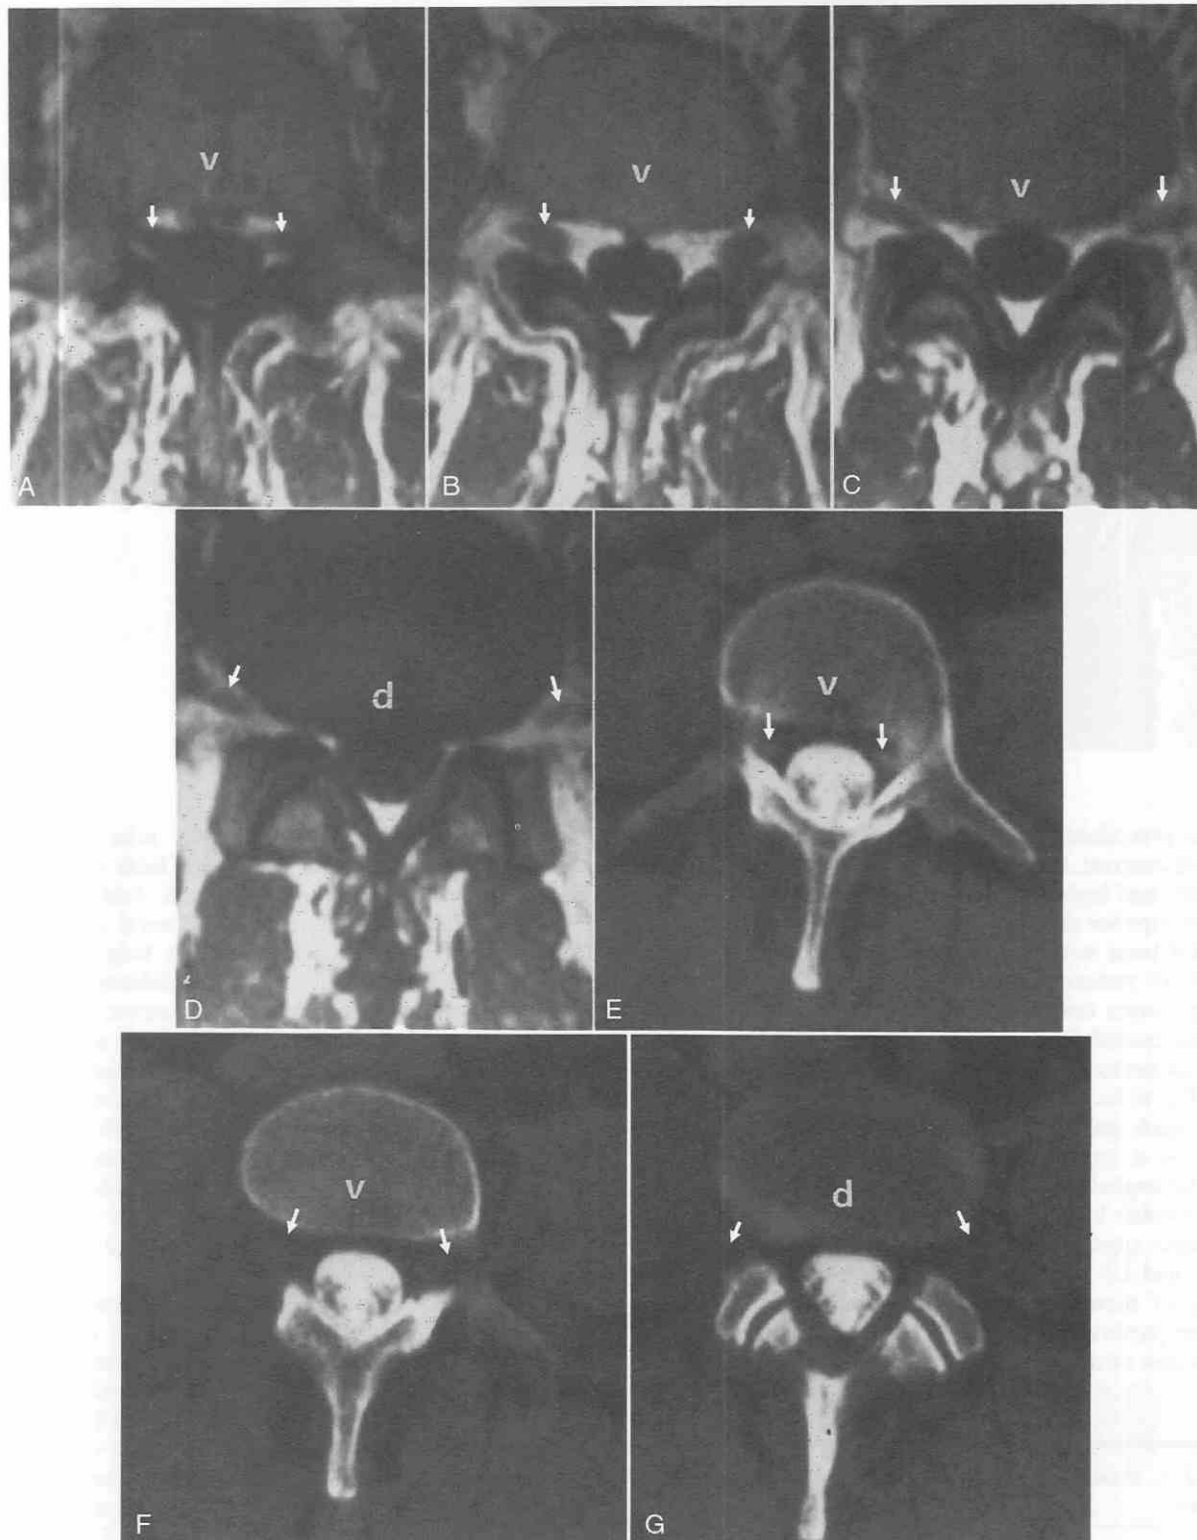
Axial T1-weighted MR image depicts the path of lumbar nerve roots through the canal. *A*, At the midbody level, the preexisting roots (*arrows*) are positioned in the lateral recesses. *B* and *C*, Just inferior to *A* at the superior aspect of the diskovertebral junction, the roots lie within the foramina. *D*, At the inferior aspect of the diskovertebral junction, the roots have already exited the foramina. *E–G*, Postmyelogram CT scan showing the same sequence of events. *d*, disk; *v*, vertebral body. Note epidural fat, bright on T1-weighted MRI and dark on CT scan, surrounding the sac and roots.
